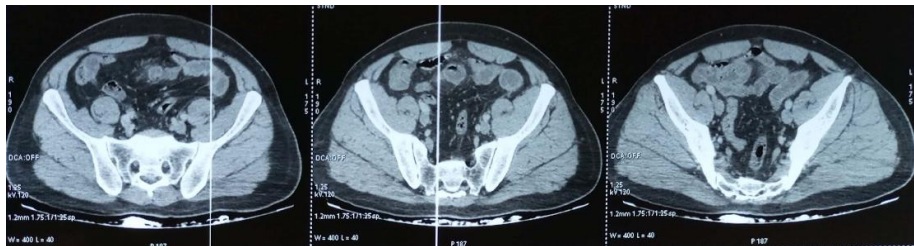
Cross-sectional abdominal CT scan showing the appendix in retro caecal position the biological check-up showed a Hb :14.9g/dl, WBC :19540/mm³, Plq : 247000/mm³
